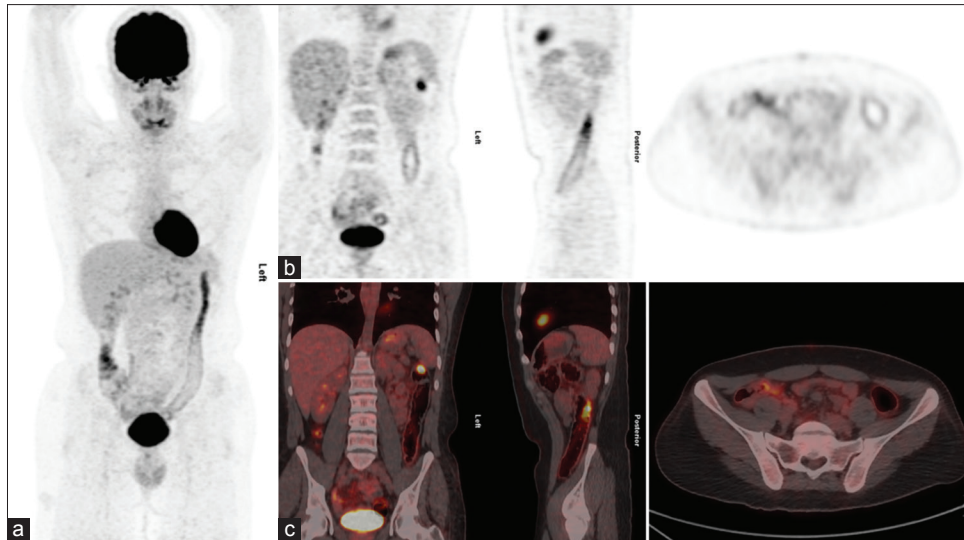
¹⁸Fluorine-fluorodeoxyglucose positron emission tomography-computed tomography is performed for restaging. (a) Maximum intensity projection fluorodeoxyglucose (b) coronal, sagittal, and transaxial images show increased tracer uptake in the ascending and descending colon. (c) Fused positron emission tomography-computed tomography images showed bowel wall thickening and colonic distension with corresponding increased tracer uptake. These findings are likely related to side effects of immunotherapy inducing secondary enterocolitis
